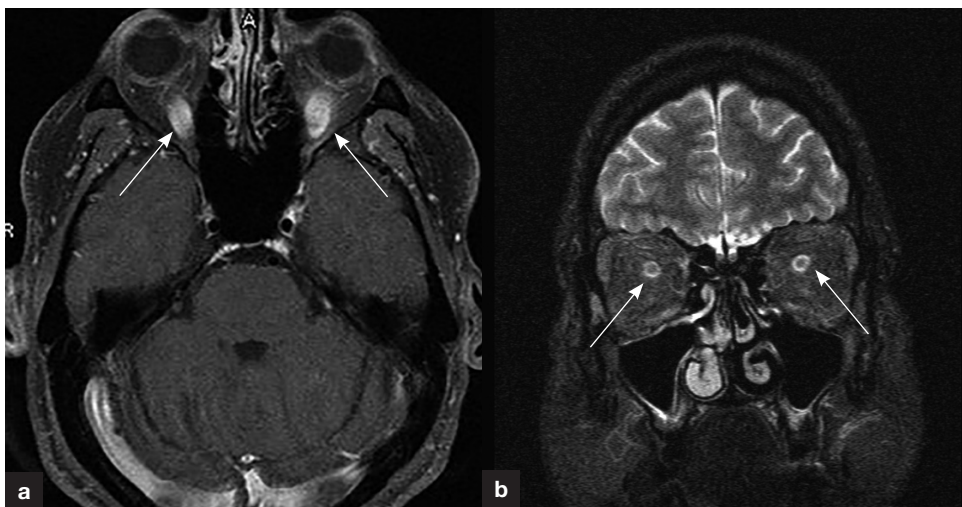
a. Axial T1-weighted and (b) coronal T2-weighted post-gadolinium magnetic resonance sequence (arrows indicating bilateral uniformly enhancing optic nerves; the nerves demonstrate moderate swelling indicating acute bilateral optic neuritis).
